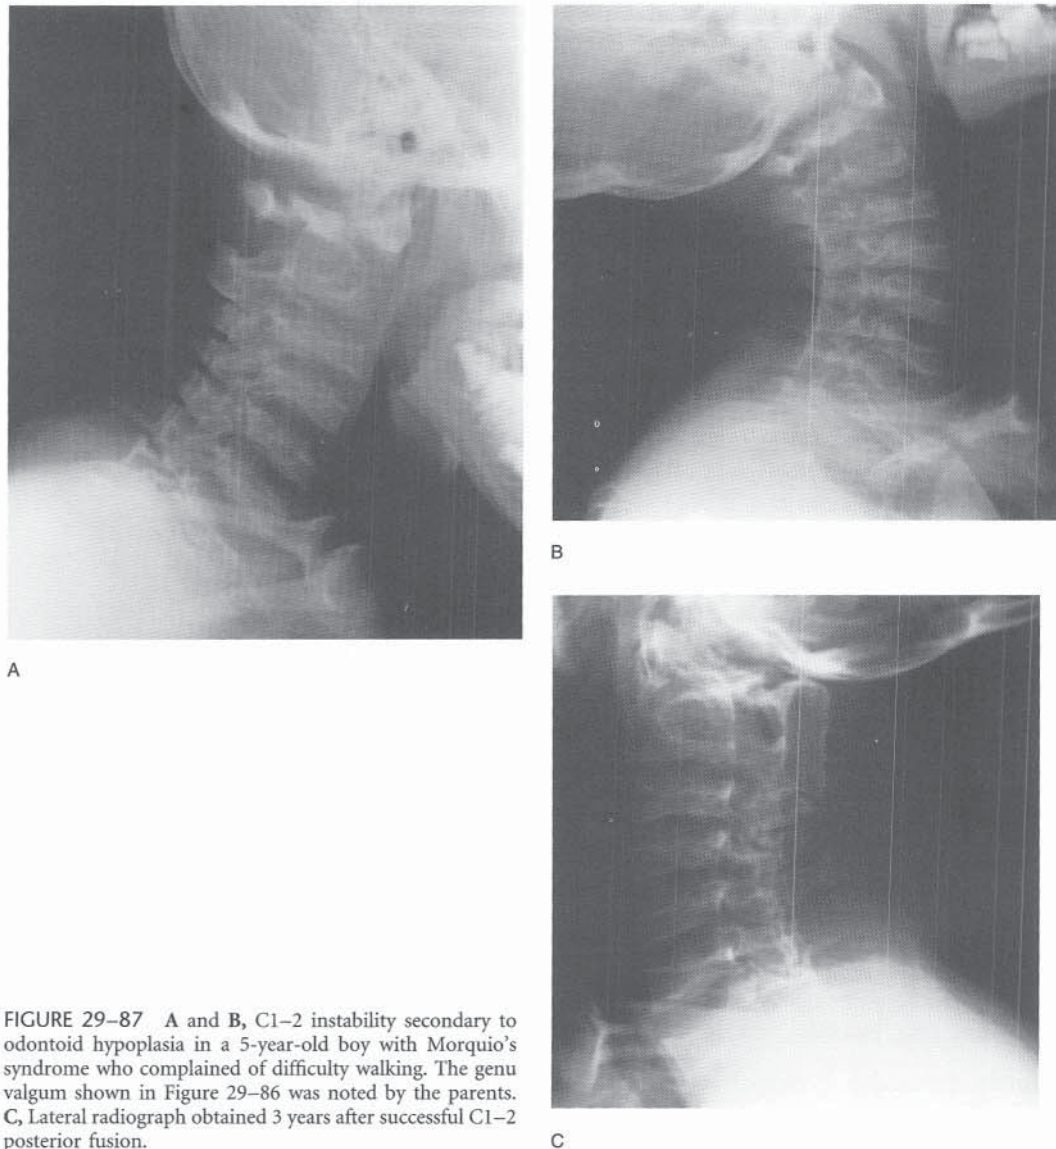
A and B, C1-2 instability secondary to odontoid hypoplasia in a 5-year-old boy with Morquio's syndrome who complained of difficulty walking. The genu valgum shown in Figure 29-86 was noted by the parents. C, Lateral radiograph obtained 3 years after successful C1-2 posterior fusion.
